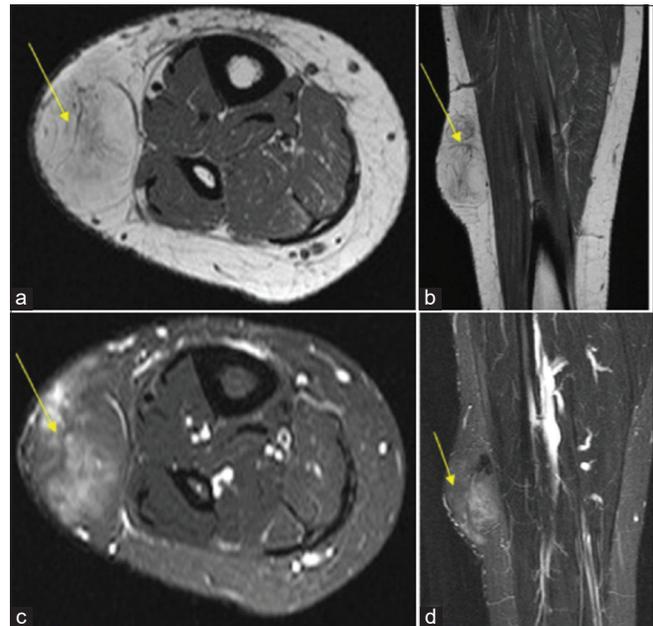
Axial T1 (a), coronal T1 (b), short tau inversion recovery (STIR) axial (c), and STIR coronal (d) magnetic resonance images of the lower leg demonstrating a subcutaneous fat signal lesion with incomplete suppression. Excision biopsy confirmed a liposarcoma.
